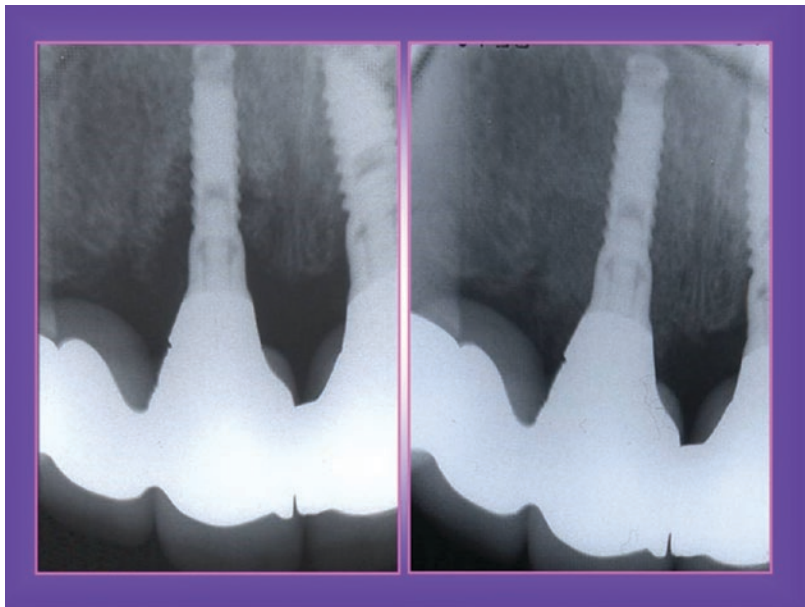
Peri-apical radiographs of the affected implant. Left: the extent of the bone destruction, Right: following surgery and use of bone graft matrix, healing at 3 months
